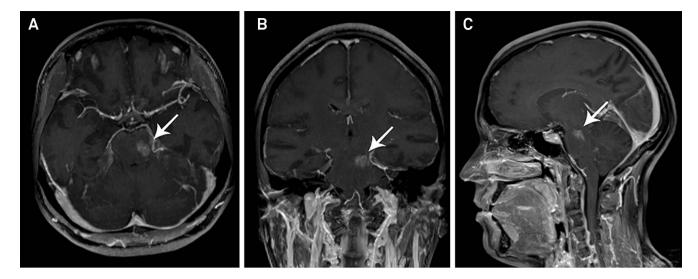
(A): MRI multiplanar reconstructions with maximum intensity projection (MIP) technique after intravenous gadolinium administration clearly demonstrates a brushlike enhancing lesion with lobulated margins; (B): Maximum lesion size is 1.4 cm, with no relevant mass effect, architectural distortion or edema in adjacent parenchyma; and (C): The occurrence of symptoms may be related to the topography and size of the lesion (dubbed as giant if larger than 1 cm in any dimension).
